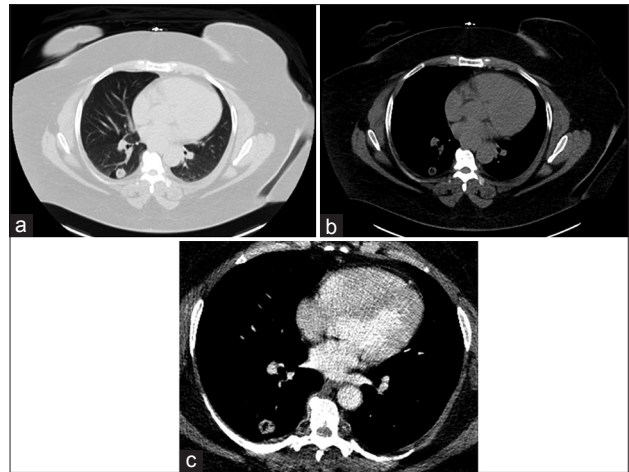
(a) Noncontrast lung window computed tomography image demonstrating a 1.8 cm, mildly spiculated right lower lobe pulmonary nodule. (b) Noncontrast axial computed tomography image demonstrating a 1.8 cm, mildly spiculated right lower lobe pulmonary nodule with punctate internal calcification and septal calcification. (c) Postcontrast administration axial computed tomography image demonstrating enhancement of the 1.8 cm pulmonary nodule in the right lower lobe
